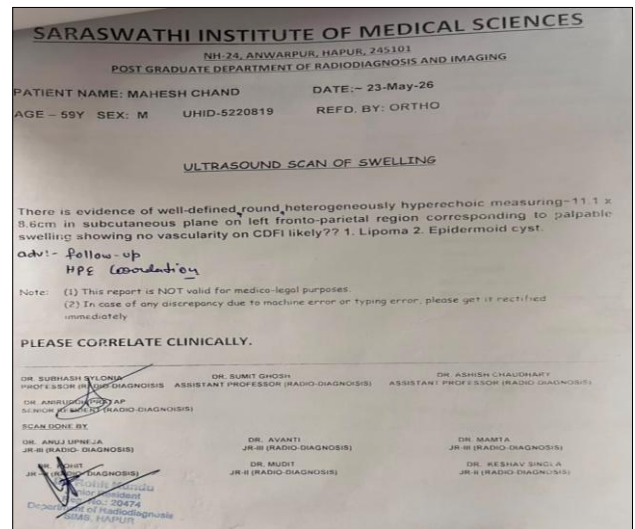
Ultrasound of scalp suggestive of subcutaneous well defined heterogeneous hypoechoic frontoparietal swelling.
